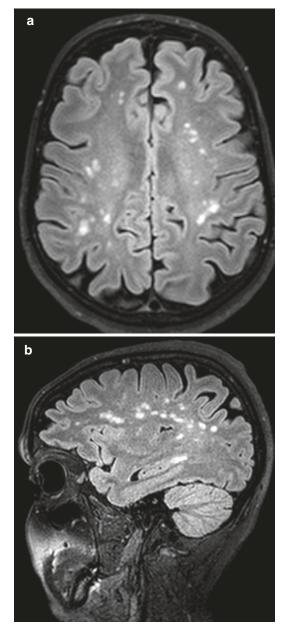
PACNS vasculitis in a 52-year-old male presenting with headache. (a) Axial and (b) sagittal T2 FLAIR demonstrating nonspecific high SI foci within deep white matter cerebral hemispheres
